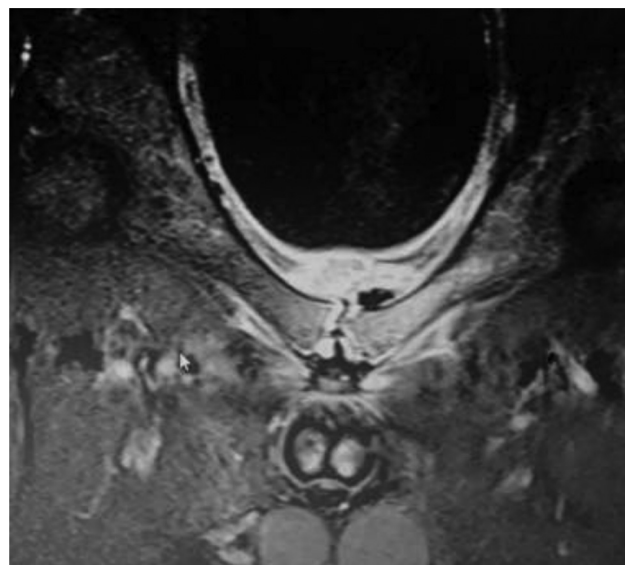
Magnetic resonance imaging of the pelvis in short inversion time inversion recovery showing a fluid collection at the pubic symphysis region.
